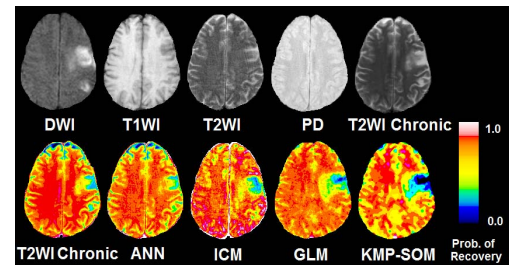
The acute DWI, T1WI, T2WI, PD and chronic T2WI of an untreated patient (first row) used for estimating the maps of probability of tissue recovery after 3 months (second row).
